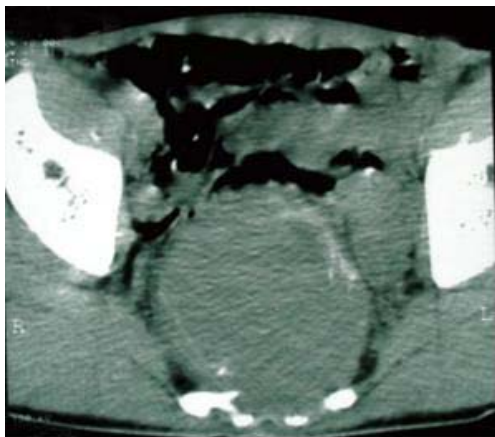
The pelvic computed tomography scan of a 32-year-old man with recurrent cell giant tumor shows bone destruction in the lower part of the sacrum (S2-S5).
